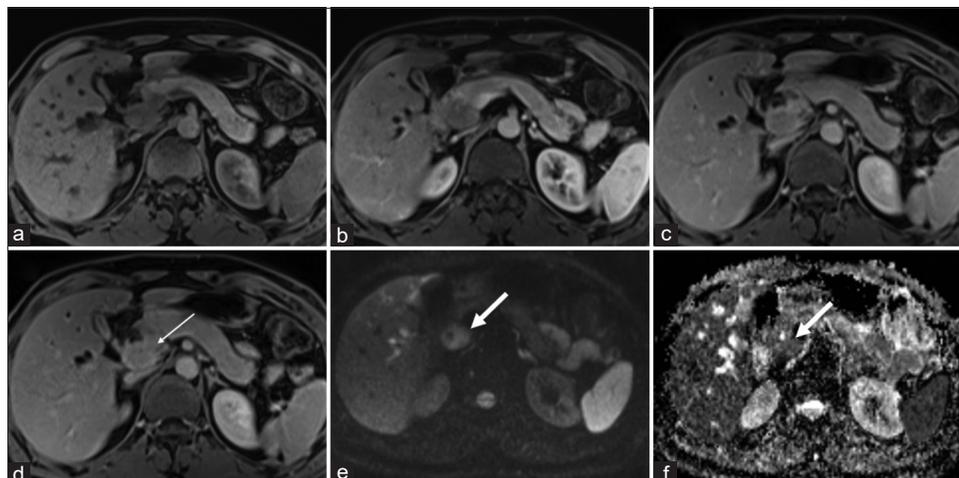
A 43-year-old man presented with porta hepatis inflammatory myofibroblastic tumor who presented with painless jaundice and pruritis. (a) axial pre contrast MR image, (b) axial post-contrast MR image in the arterial phase, (c) axial post-contrast MR image in porto venous phase, and (d) axial post-contrast MR image in delayed phase show a heterogeneously enhancing mass at the porta hepatis. The mass is of intermediate T1 signal intensity with no fat component. The mass shows mild arterial enhancement with progressive enhancement throughout the delayed phases [thin white arrow]. (e) axial DWI image and (f) corresponding axial ADC image show mild diffusion restriction [bold arrow]. No vascular invasion was identified.
